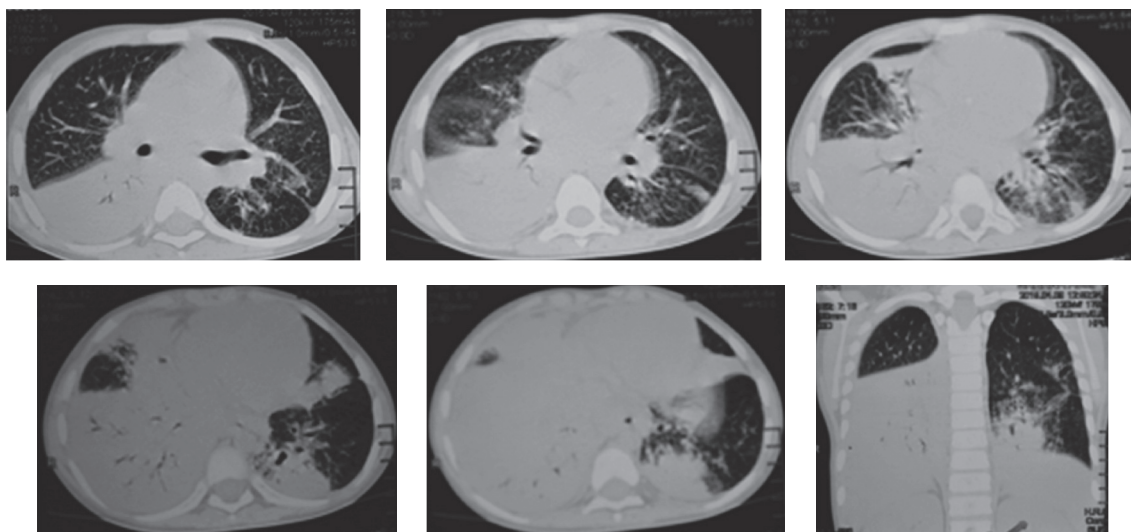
A 7-year-old female patient. A. HRCT image shows lobar consolidation with presence of air bronchogram in right lower lobe of lung. Segmental areas of consolidation are seen in the medial segment of middle lobe, inferior lingular segment and posterior basal segment of left lower lobe. Diffused ground glass appearance of the visualized lung field with patchy normal areas is seen.
